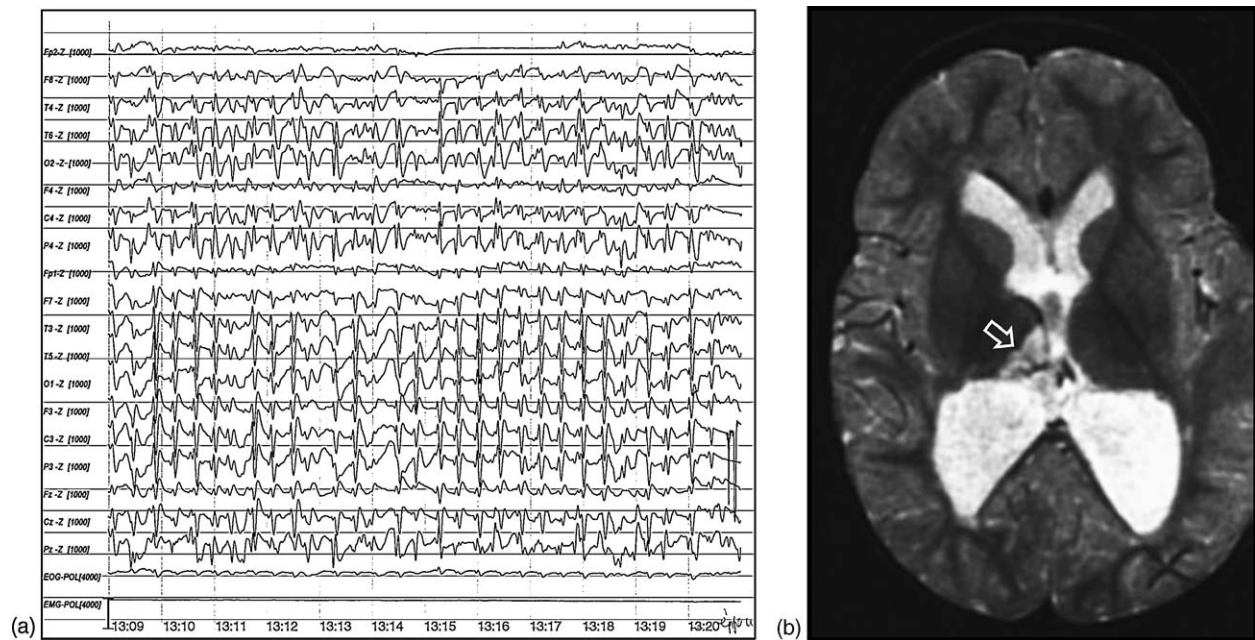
Patient 2: (a) EEG: ESES; (b) axial T2 weighted MRI: perinatal lesion in the right thalamus (arrow), mild hydrocephalus.
